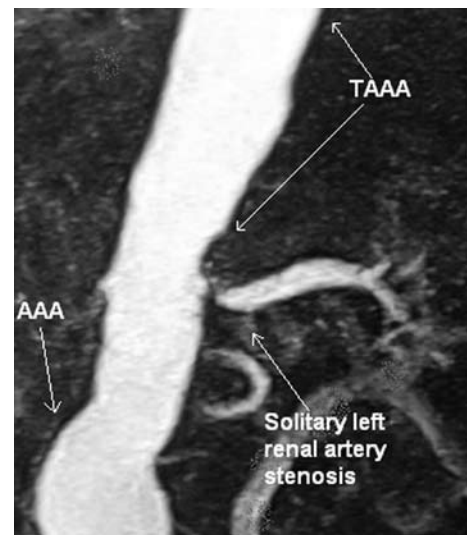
Computed tomography angiogram demonstrating the TAAA, AAA and solitary left renal artery stenosis.
